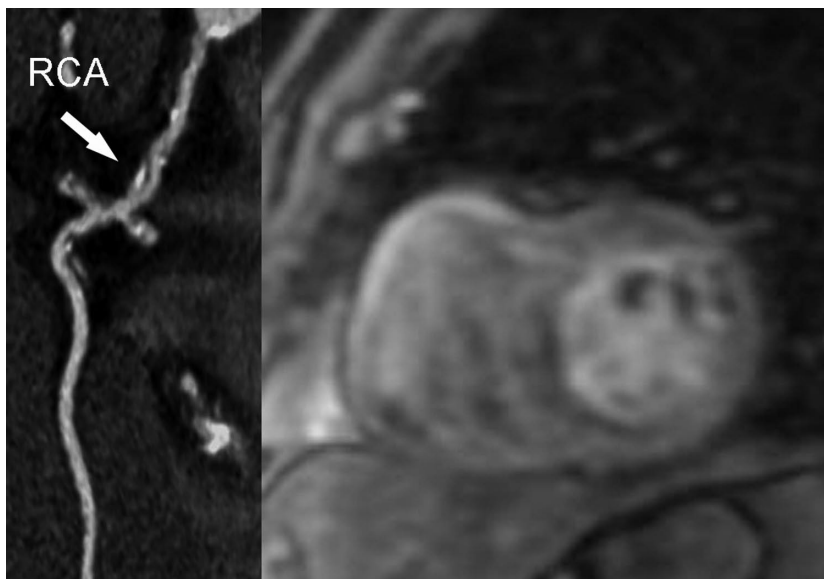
Patient with a significant lesion in the RCA on CTCA (Left) and a perfusion defect in the infero-septal wall on MRP (Right), the CFR in this patient was 1.9. CFR, coronary flow reserve; CTCA, computed tomography coronary angiography; RCA, right coronary artery.
